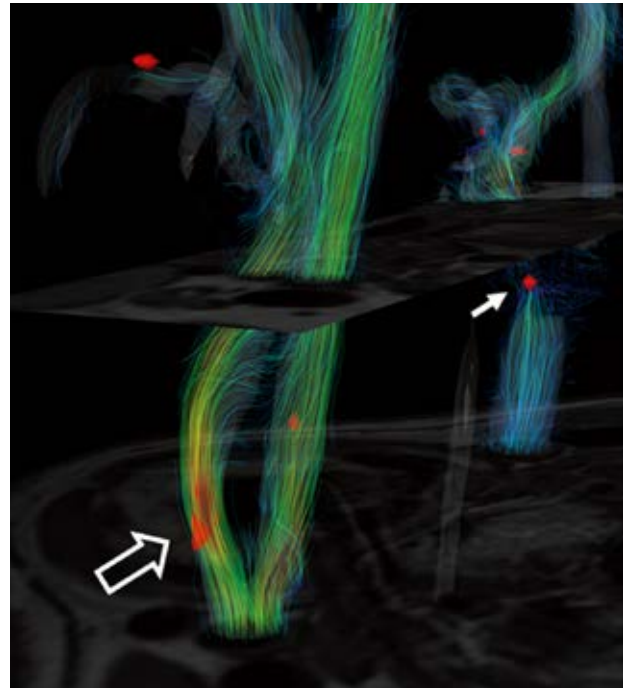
MRI turbulence data from a patient with carotid artery stenosis. The intensity of turbulence is graded according to a color scale, showing areas with a lot of turbulence in red and yellow downstream from a carotid artery stenosis (solid arrow) and at the outer wall of the contra-lateral internal carotid artery (open arrow).
